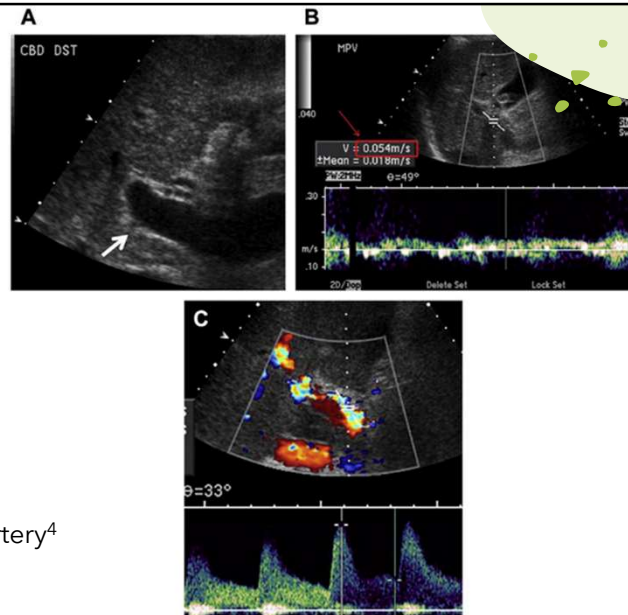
Ultrasound images of portal hypertensive patient demonstrating a dilated main portal vein (a), slow MPV flow (b), and increased hepatic artery flow (c).
